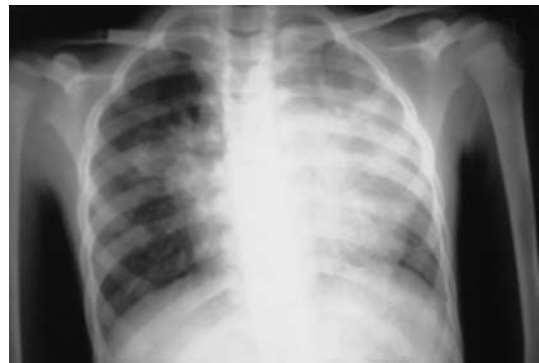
PA chest X-ray: left upper and middle zone homogenous and right perihilar nodular consolidation.
